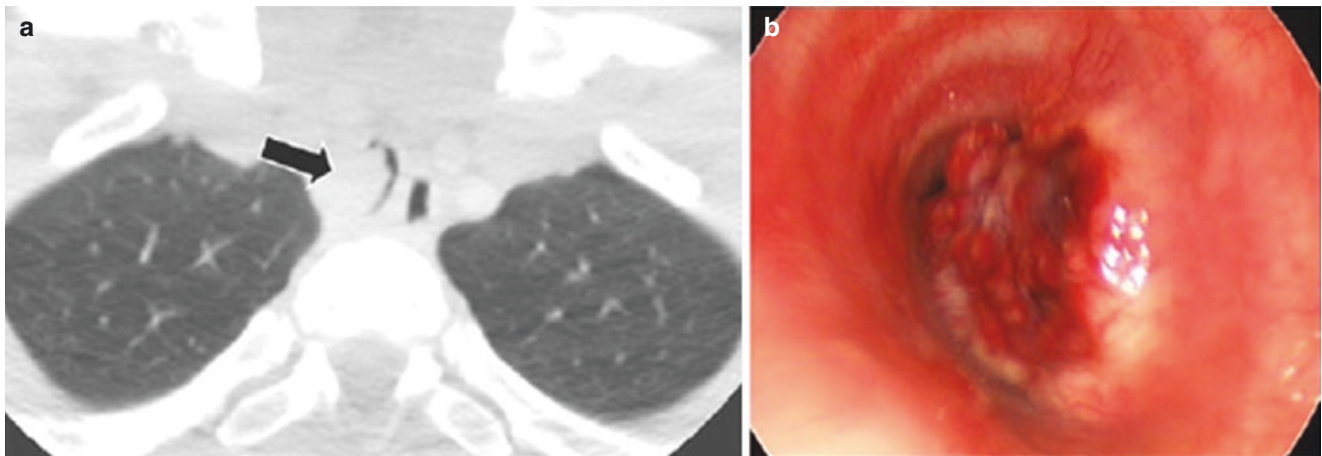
A 5-year-old boy who presented with progressively worsening shortness of breath. (a) Axial lung window CT image demonstrates a large intratracheal mass (arrow) almost completely obstructing
